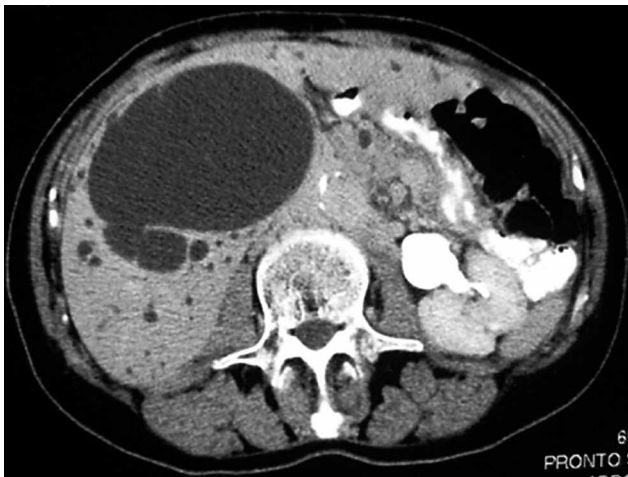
CT scan showing hypodense mass with incomplete septations.
